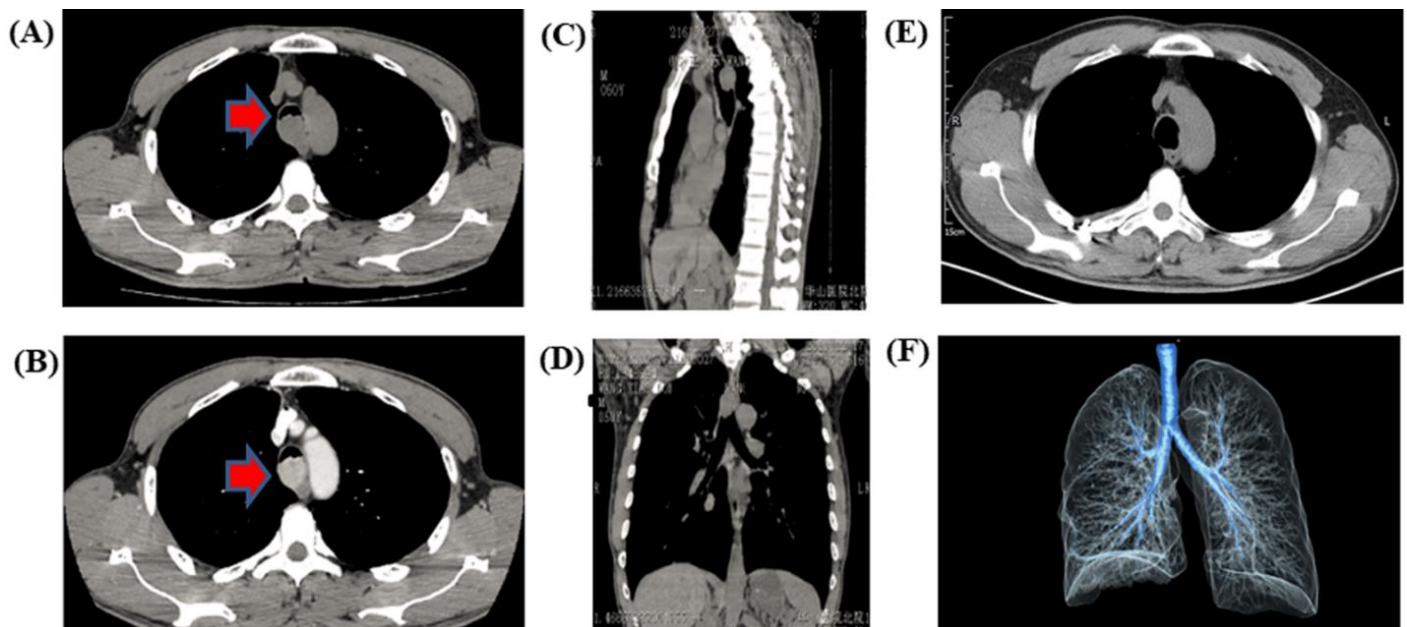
Chest CT demonstrating a polypoid endotracheal tumor. Notes: (A) (mediastinal window), (B) (enhanced CT), (C) (coronary position, 3D reconstruction) and (D) (sagittal position, 3D reconstruction) preoperative chest CT images showing tracheal obstruction by a lobulated heterogeneous enhancing soft tissue lesion; (E) and (F) postoperative chest CT images showing that the trachea was well without a tumor.
